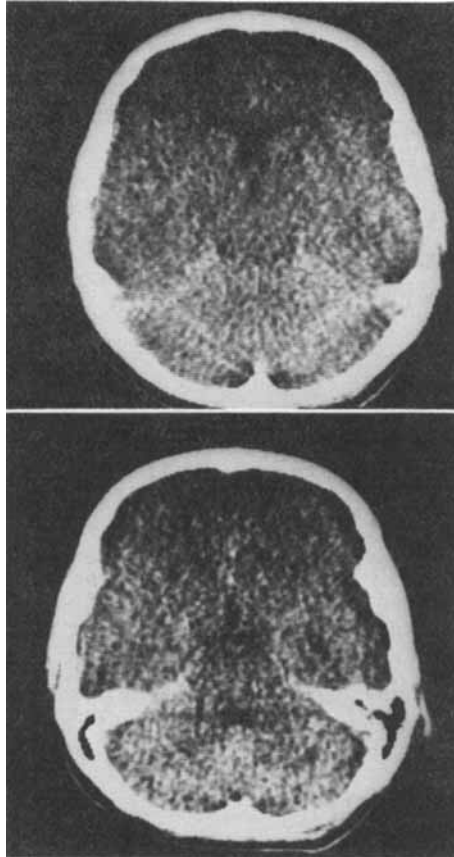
Non-enhanced CT scan of the brain, performed ten hours after the ingestion of SFMA.
